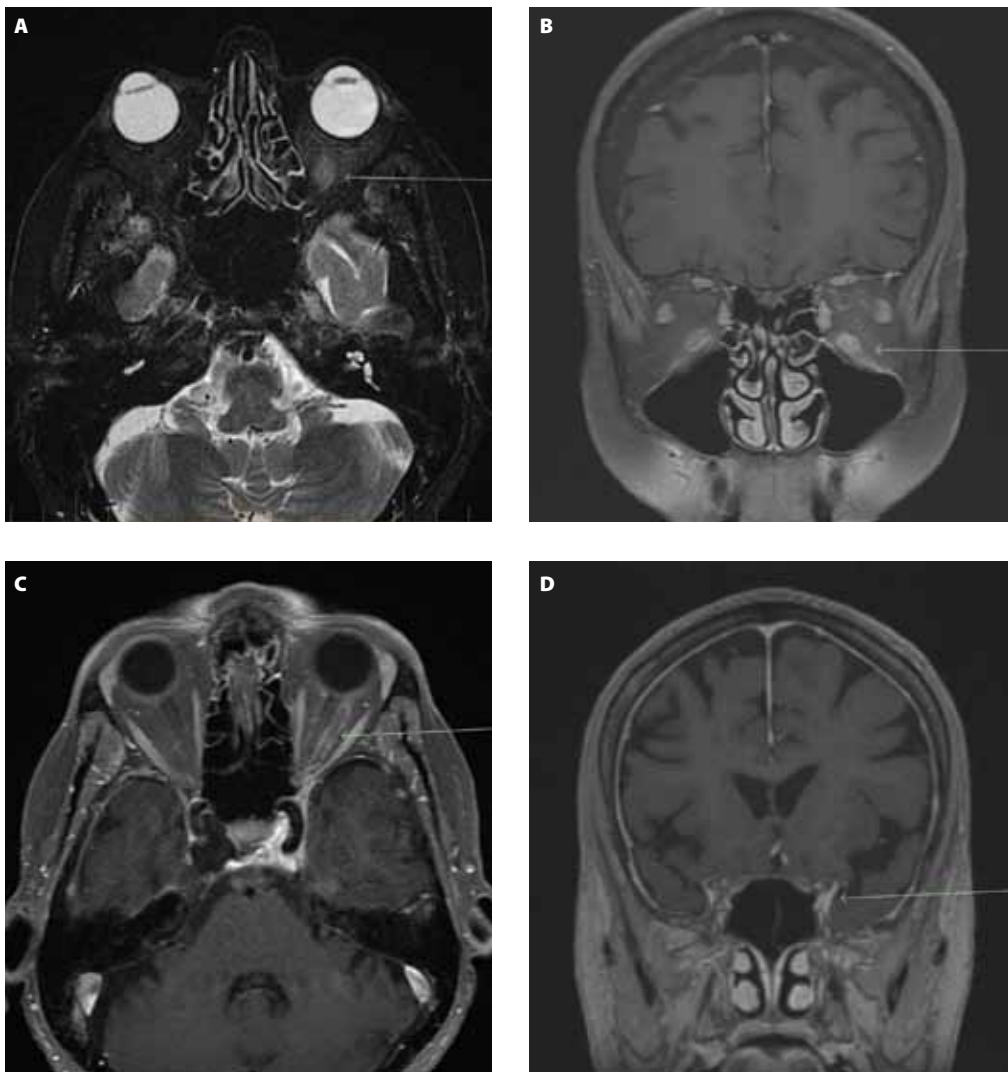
MRI of the orbit, showing left inferior rectus edema (A) and enhancement (B), retrobulbar enhancement (C), and superior orbital fissure enhancement (D).
